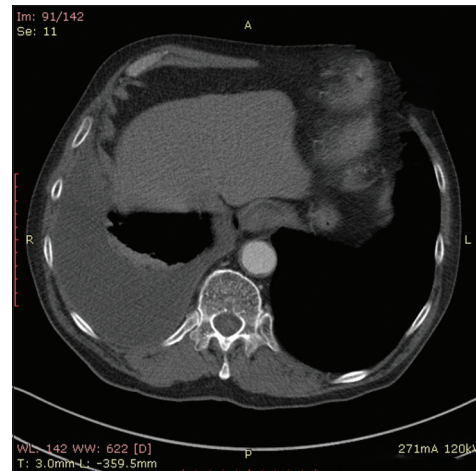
Chest CT scan showing pleural effusion without thickening of the pleura
